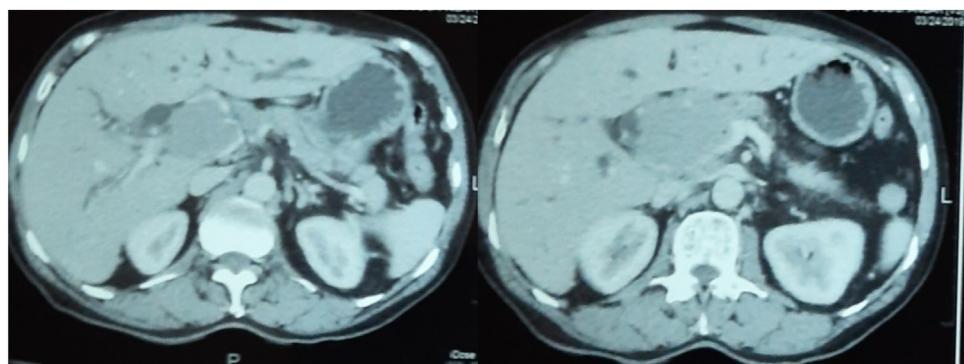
CT shows Pancreatic head and uncinate process mass.
